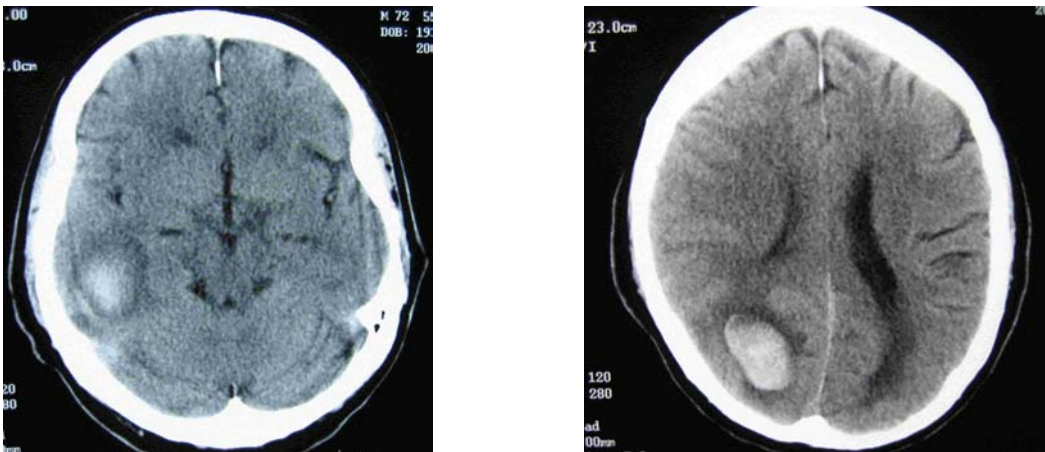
CT Scan of the head (equivalent cuts to original scan)
